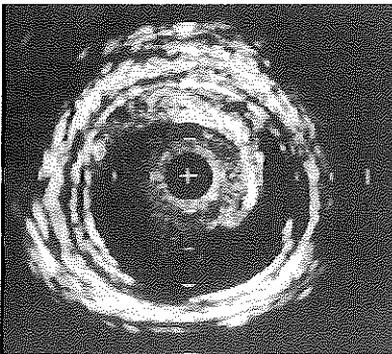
Intravascular ultrasound cross-section obtained from a patient after balloon angioplasty of the superficial femoral artery. The lesion involved, eccentric and soft in nature, became dissected from the arterial wall. Both the extent of the dissection (between 2 and 4 o'clock) and media rupture were 2 h (at 3 and at 7 o'clock). + = catheter; calibration = 1 mm.
